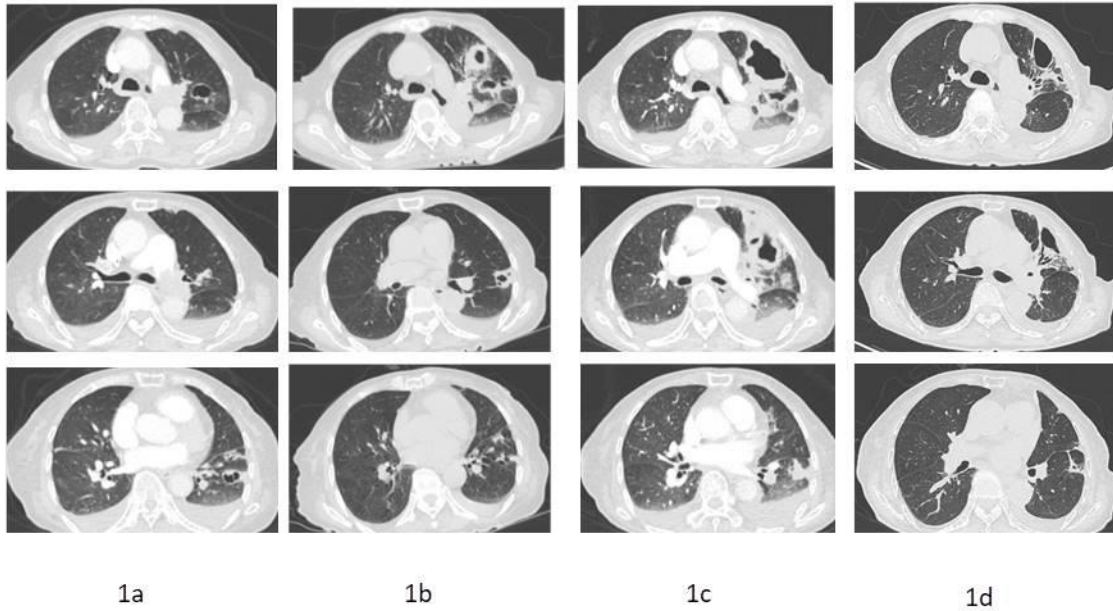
Chest CT of the patient
